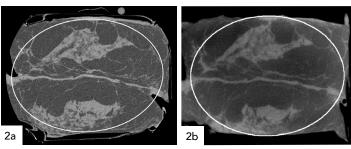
Ductal carcinoma in situ, grade 2; size,  $13 \text{ cm} \times 18 \text{ cm}$ . Figure 2a: PBCT, 35 keV and 9-m sample-to-detector distance. Figure 2b: Koning CBCT. Both images approximately 5.8 mGy. PBCT image is courtesy of Elettra Sincrotrone Trieste, Italy.
